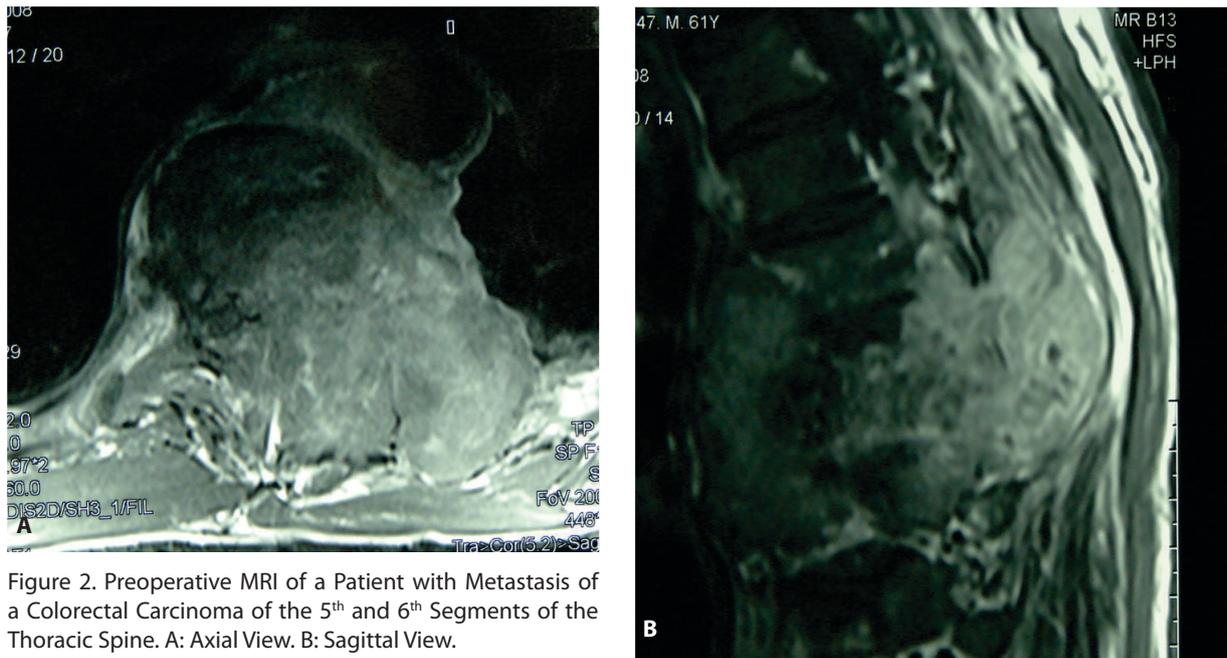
Preoperative MRI of a Patient with Metastasis of a Colorectal Carcinoma of the 5th and 6th Segments of the Thoracic Spine. A: Axial View. B: Sagittal View.
